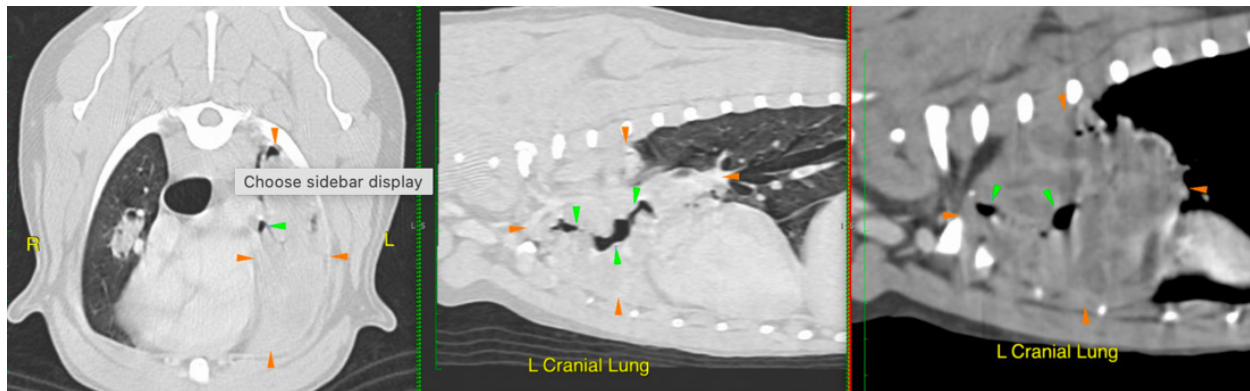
CT scan of the thorax showing an extensive lesion suspected to be a mass affecting the left cranial and middle pulmonary lobes causing distorted narrowed airways. Orange arrowheads demarcate the mass and green arrowheads demarcate the airways.
